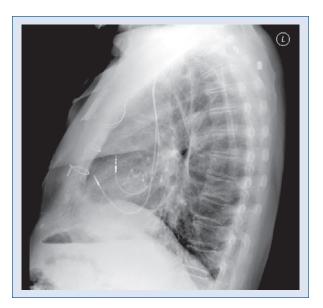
Chest X-ray: lateral view, demonstrating correct placement of atrial and ventricular leads.
